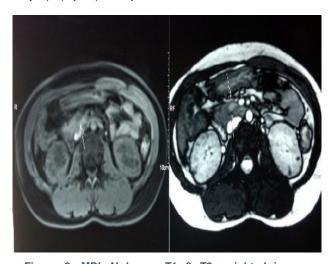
MRI Abdomen T1 & T2 weighted images showing well defined lesion (white arrow) in the uncinate process of pancreas
